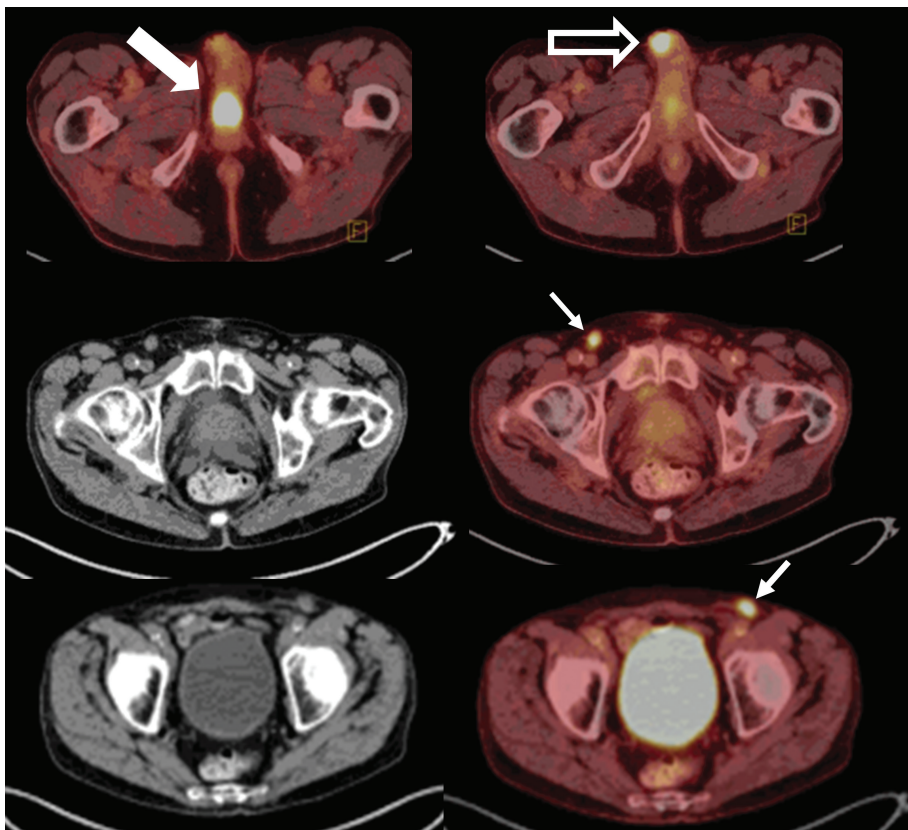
Penile base, surgical site, and lymph nodes. FDG PET/CT demonstrates hypermetabolic activity within the penile base (thick solid arrow), surgical site (thick open arrow), and bilateral inguinal lymph nodes (thin arrows). This patient was status post partial penectomy and chemotherapy for penile squamous cell carcinoma. Findings on PET/CT were consistent with progression of disease and poor response to chemotherapy.
